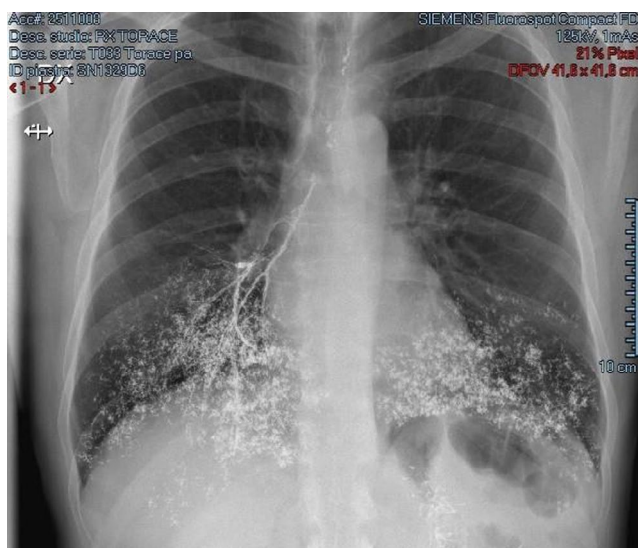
X-Ray chest image showing bilateral opacification of bronchial tree
